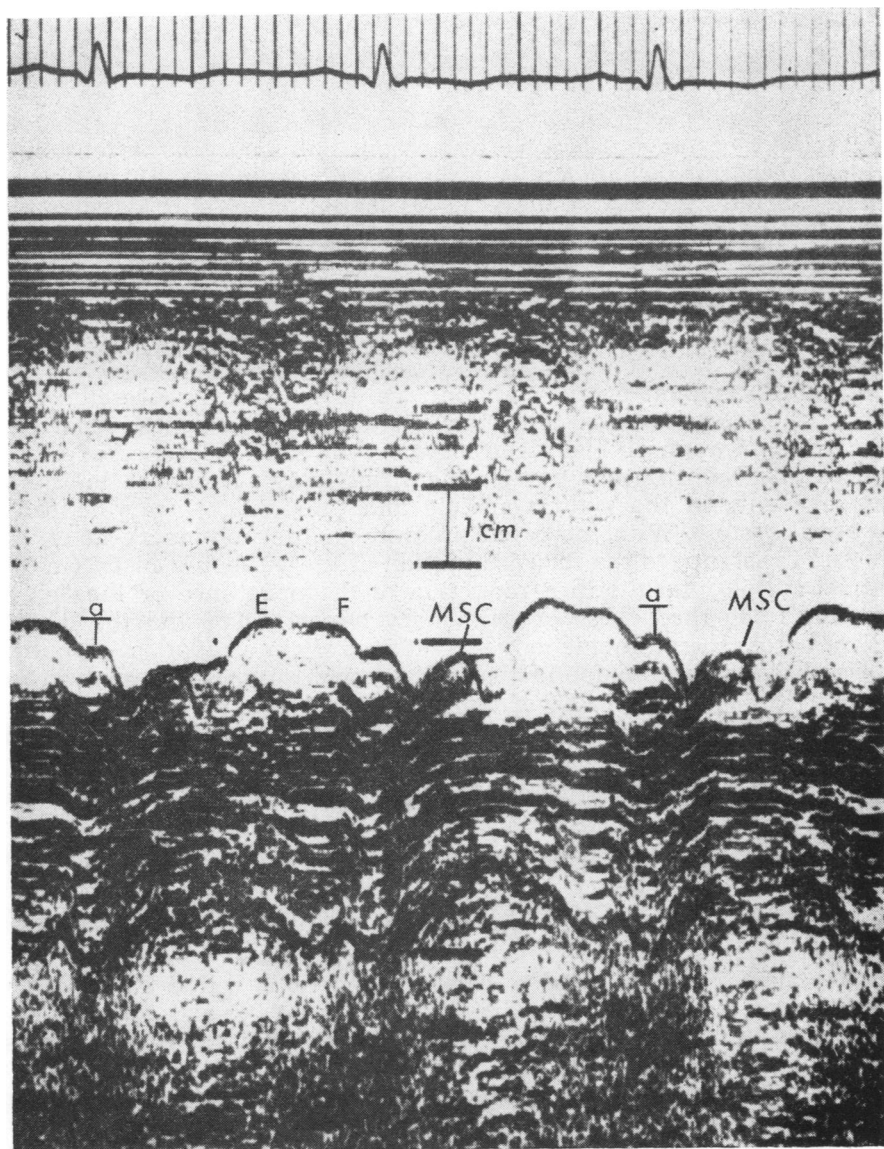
Echocardiogram of the pulmonic valve showing prominent "a" dip (4 mm), decreased EF slope, and mid-systolic closure of the pulmonic valve (MSC).
